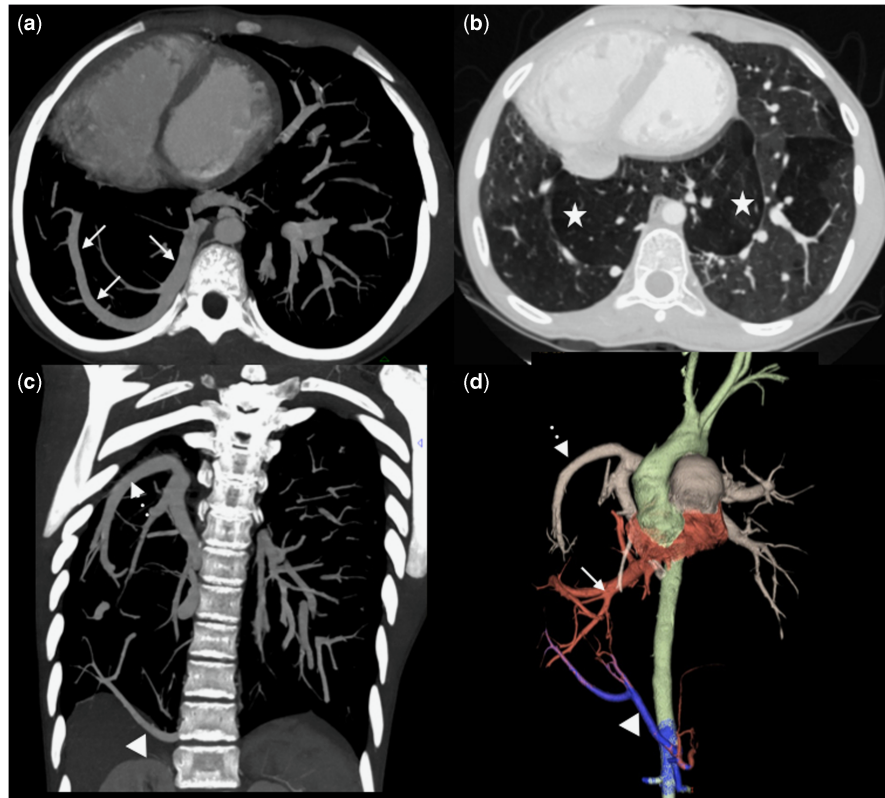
Images from CT chest with contrast. Axial images (a and b) showing the horseshoe morphology right lower lobe (star) and unusual course of the right inferior pulmonary vein draining into the left atrium (arrow). Coronal maximum intensity projection image (c) and 3D rendered image (d) showing the right pulmonary artery (broken arrow) and a branch from the celiac artery (arrow head).
